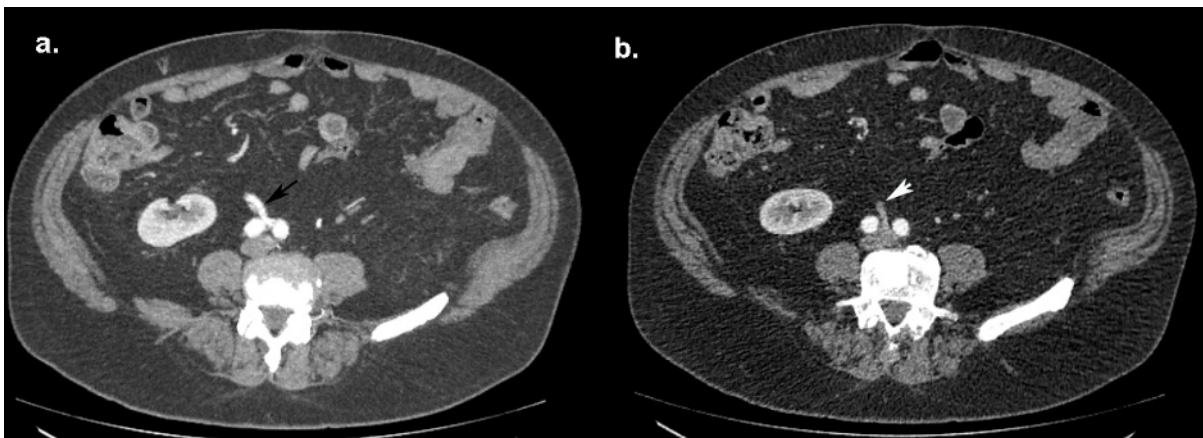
Axial plane of abdominal computed tomography angiography in the arterial phase showing a) maximum intensity projection (MIP) at the level of the inferior right renal artery that is originated from the left common iliac artery (black arrow) and b) at the level of the inferior right renal vein that drains to the left common iliac vein (white arrowhead).
